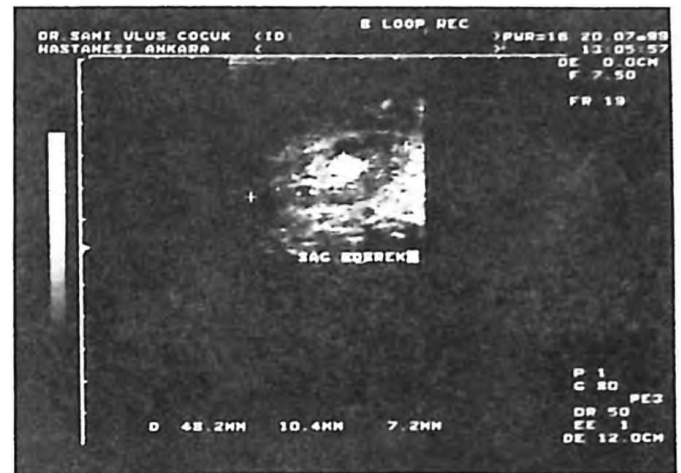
Renal ultrasonography showing increased echogenicity on the right kidney.
